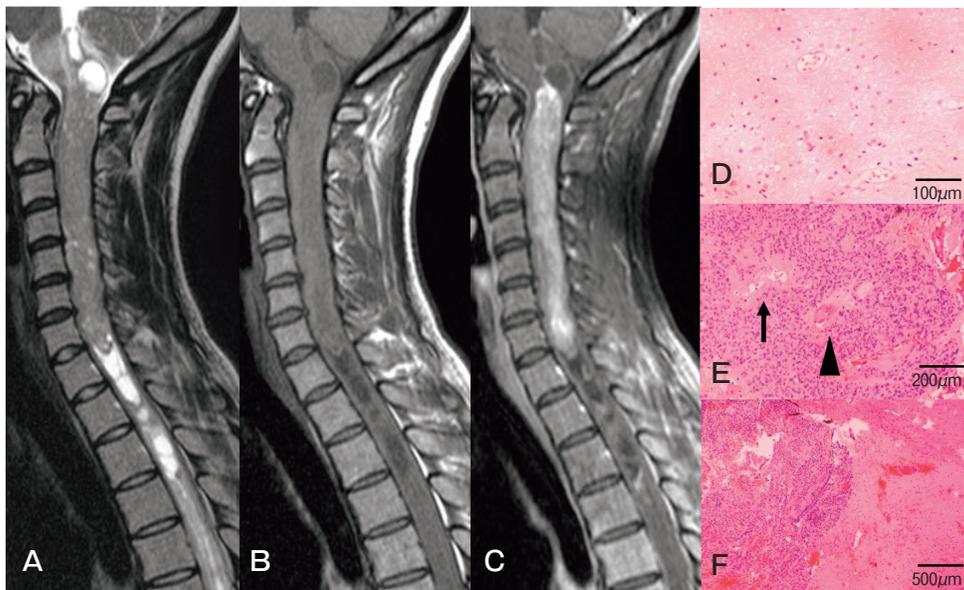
Case 2. Low-signal-intensity T2-weighted MRI (A), high-signal-intensity T1-weighted MRI (B), and Gd-DTPA-enhanced tumor (C). IPD based on the biopsy: small glial cells containing homogeneous nuclei (astrocytoma) (D). FPD based on the final resection: true rosettes (arrow) and perivascular pseudorosettes (arrowhead) (E). Gliosis around the ependymoma (F).
